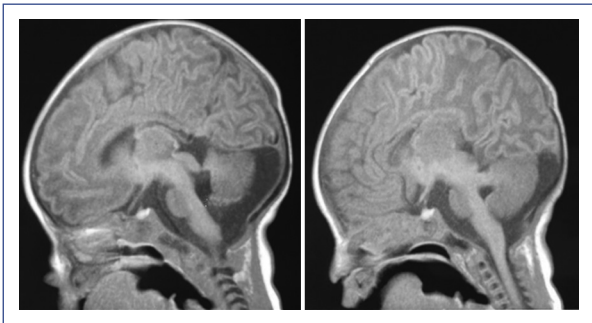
Brain MRI, T1, sagittal and parasagittal planes, showing hypoplasia and dysplastic aspect of the superior cerebellar vermis and cerebral hemispheres, associated with folial disorganization and wide cisterna magna, in addition to thinning of the corpus callosum.
